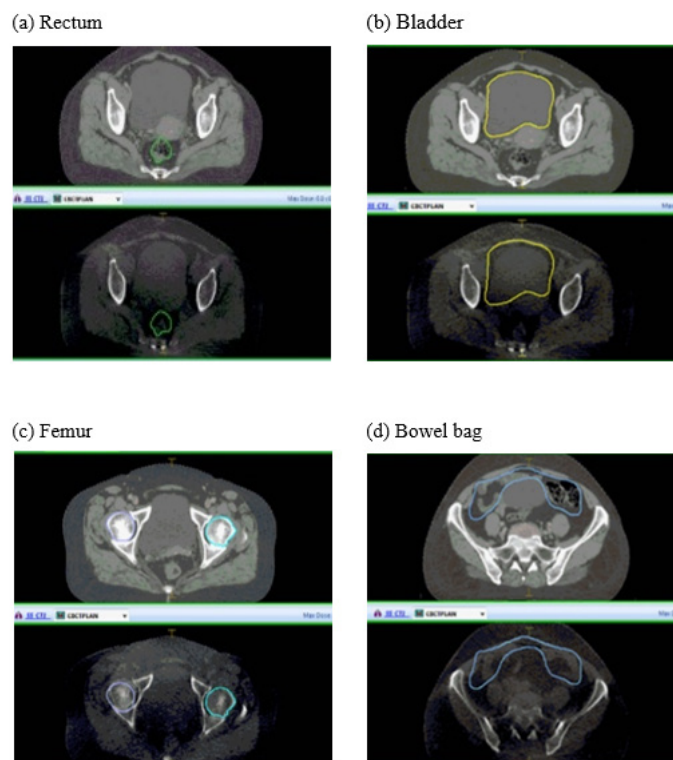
Rectum, Bladder, Femur and Bowel Bag Contoured on Routine CT and kVCBCT Images
